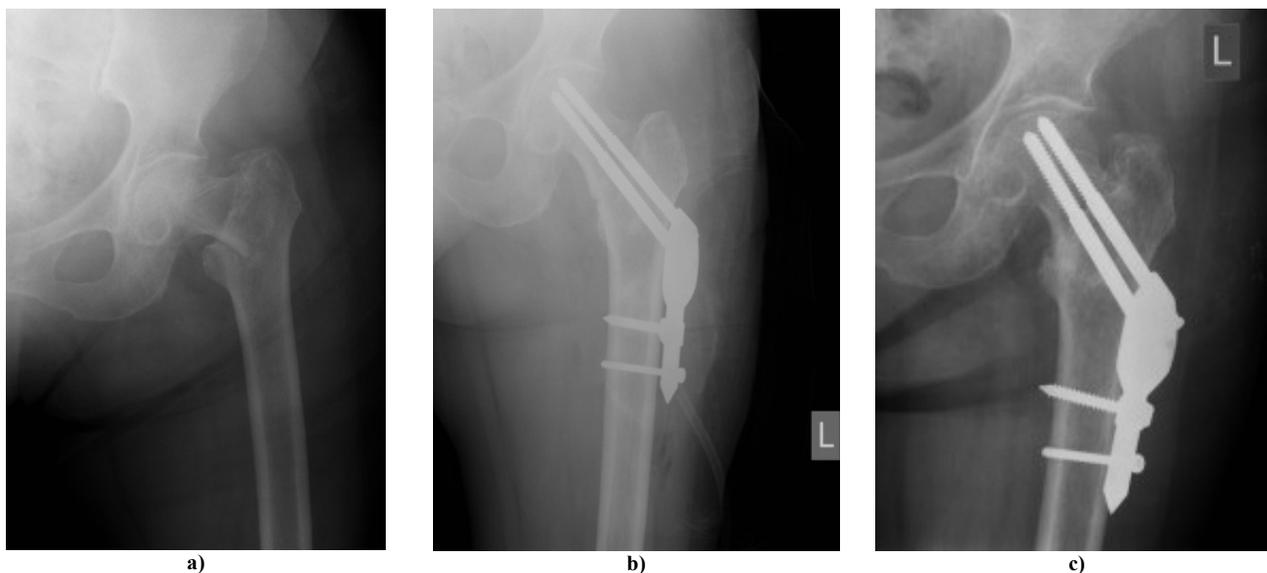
Radiographs of a 81-year-old female patient with stable osteoporotic intertrochanteric fractures (AO type 31-A1.2).
